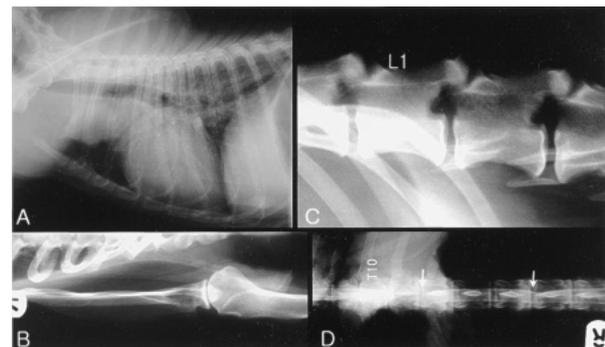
(A) Lateral thoracic radiograph showing a soft tissue mass in the cranial mediastinum that *displaced* the trachea dorsally. (B) Lateral view of the thoraco-lumbar vertebrae and (C) caudocranial view of the right shoulder joint demonstrating the bone lysis in the L2 and right scapula, respectively. (D) Myelogram after cisternal puncture indicating the extradural spinal cord compression at the level of T11 and L2 (arrows).
